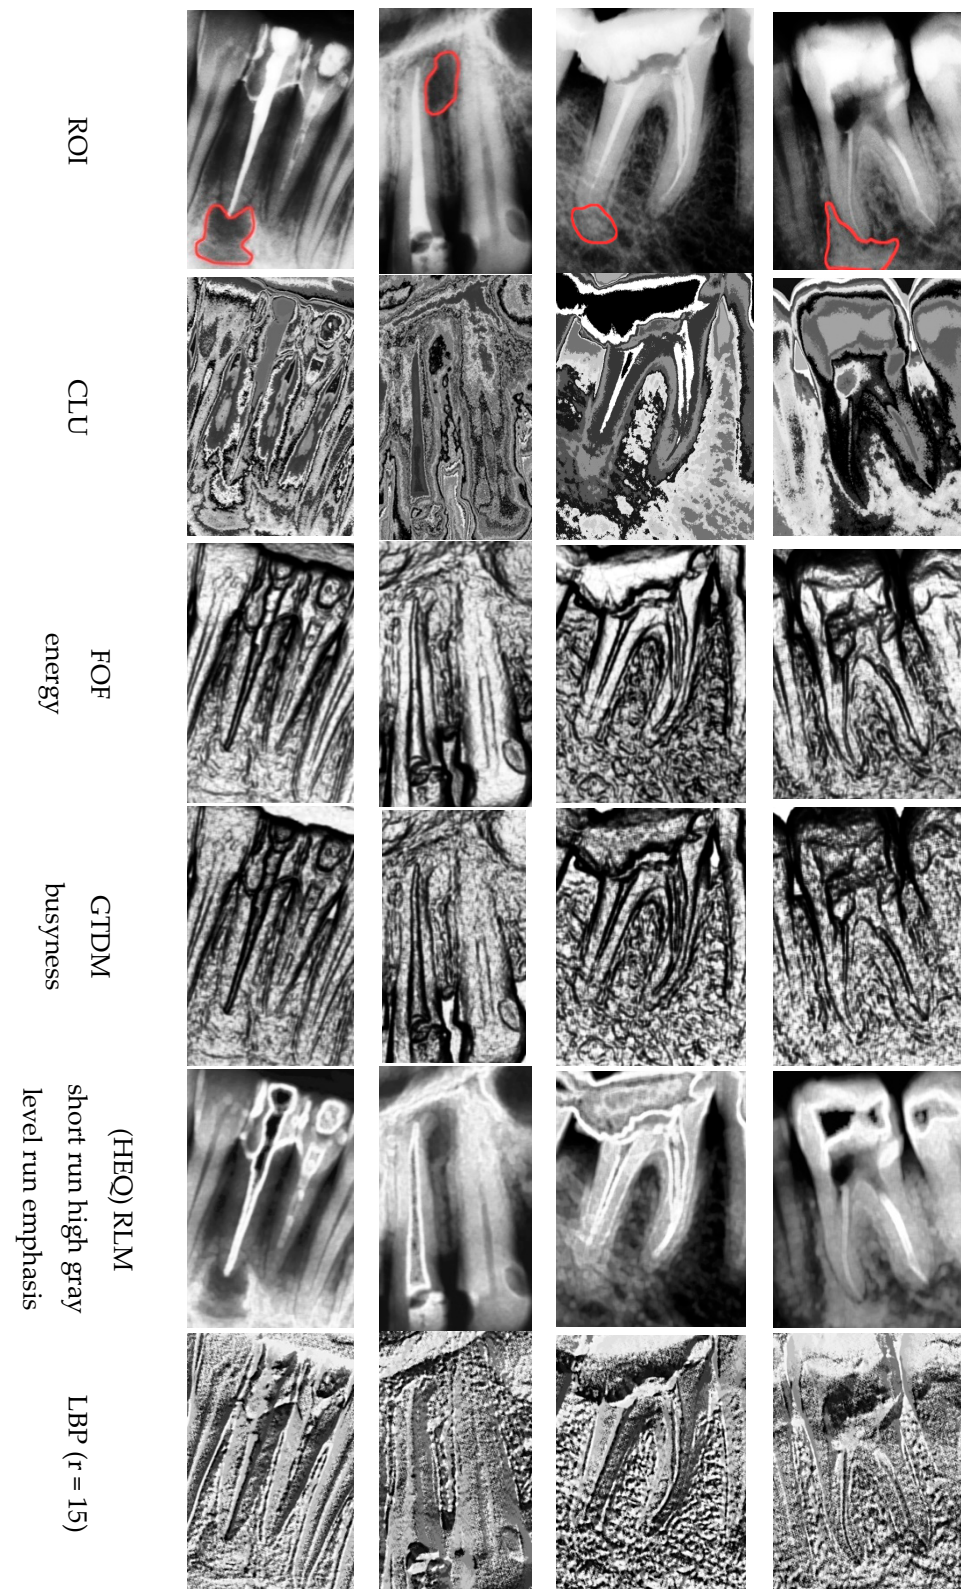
Example of assessment of a periapical lesion.
